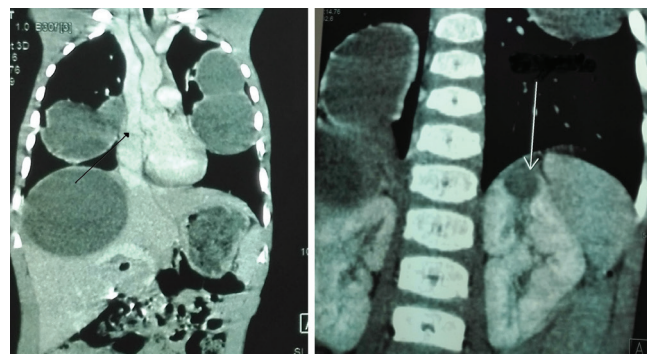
Computed tomography scan shows large, cystic, multilocular lesions in both lungs, liver, and left kidney (white arrow). The black arrow shows the intrapericardial superior vena cava and the right atrium.
